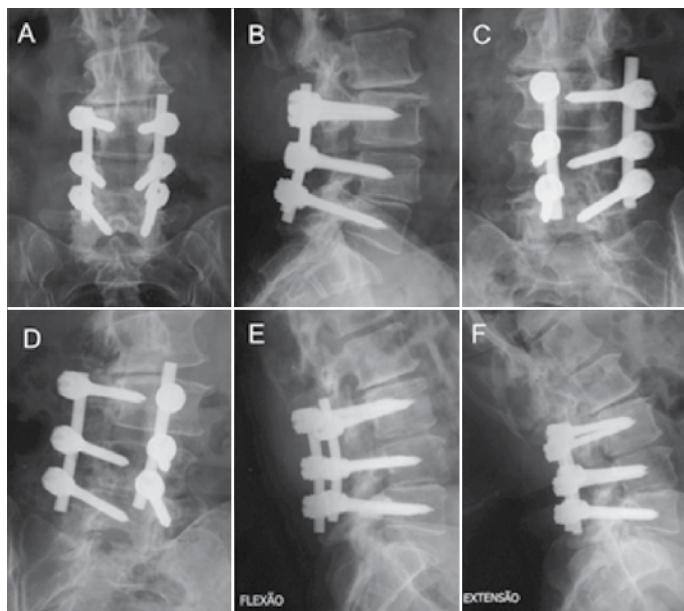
Case 1: (A and B) AP and lateral radiographs at 1 year postoperatively, showing the positions of the pedicle screws at L3, L4, and L5, with no signs of loosening of the material, (C and D) radiographs in oblique view showing the consolidation of the arthrodesis (Classified as Linovitz Grade II), (E and F) dynamic radiographs showing no movement.
